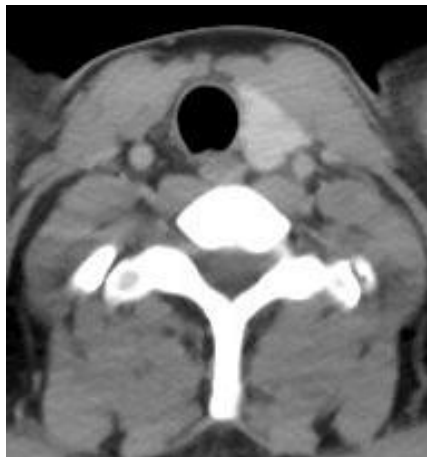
Contrast enhanced computed tomography scan axial section of lower neck showing normal left thyroid lobe, absent right thyroid lobe and isthmus.
